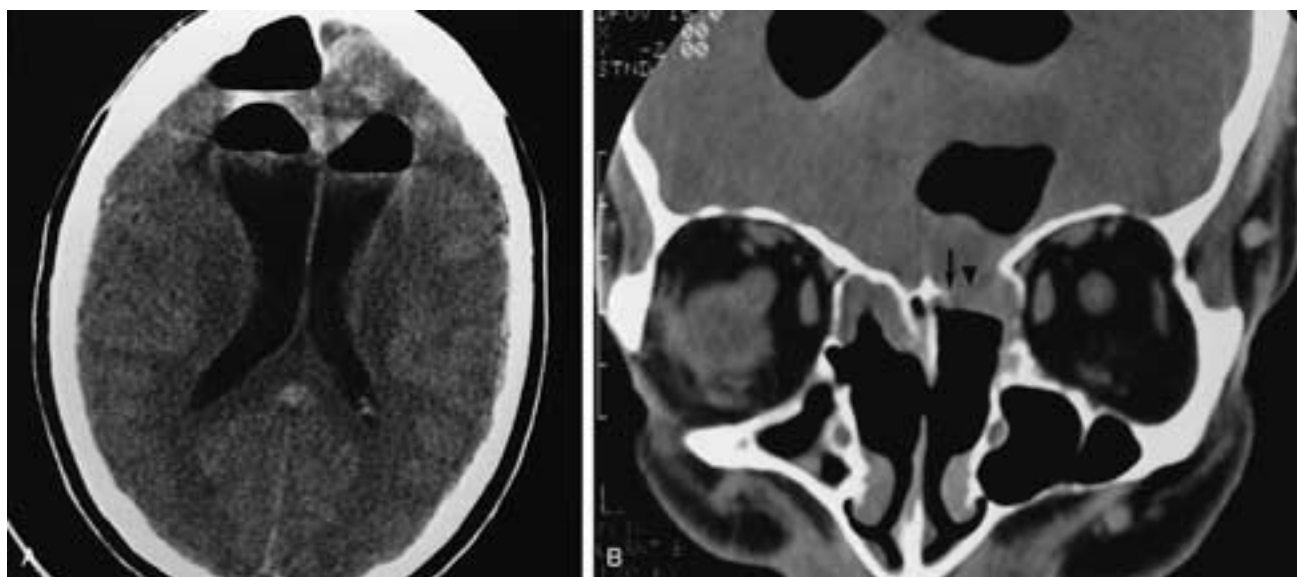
Anterior skull base defect with pneumocephalus. The patient presented with headaches immediately following FESS. A CT scan was obtained several days after FESS, revealing pneumocephalus and an anterior skull base defect. A, Axial CT scan shows massive intracranial air, including intraventricular air. This implies that the surgical instruments went through the bony anterior skull base. B, Direct coronal CT scan shows resection of the entire left middle turbinate, cribriform plate (*arrow*), and roof of the ethmoids (*arrowhead*).
